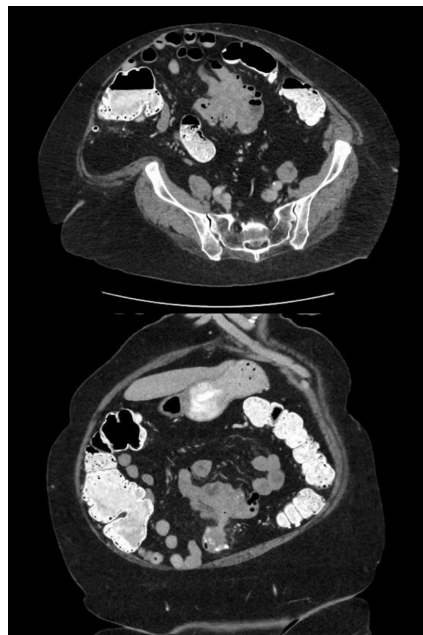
Pre-operative CT demonstrating colo-jejunal fistula
